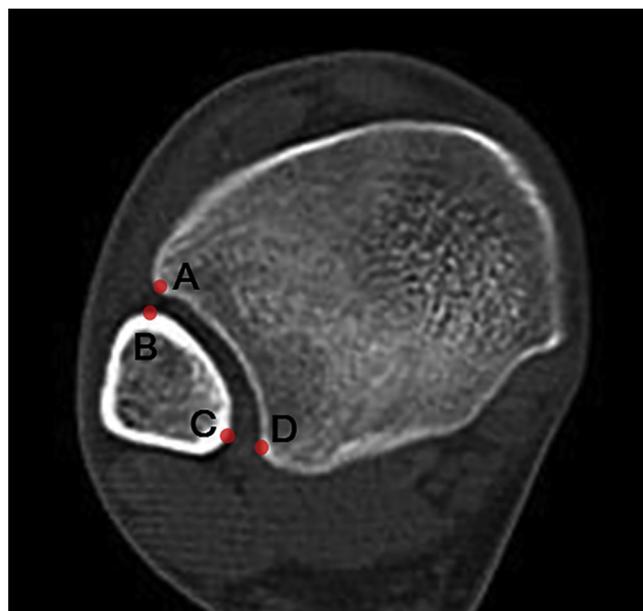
Axial computed tomography image of the right ankle approximately 1 cm proximal to the tibial plafond in a normal syndesmosis in a 40-year-old man. The anterior tibiofibular clear space is the distance between points A and B, and the posterior tibiofibular clear space is the distance between points C and D.
